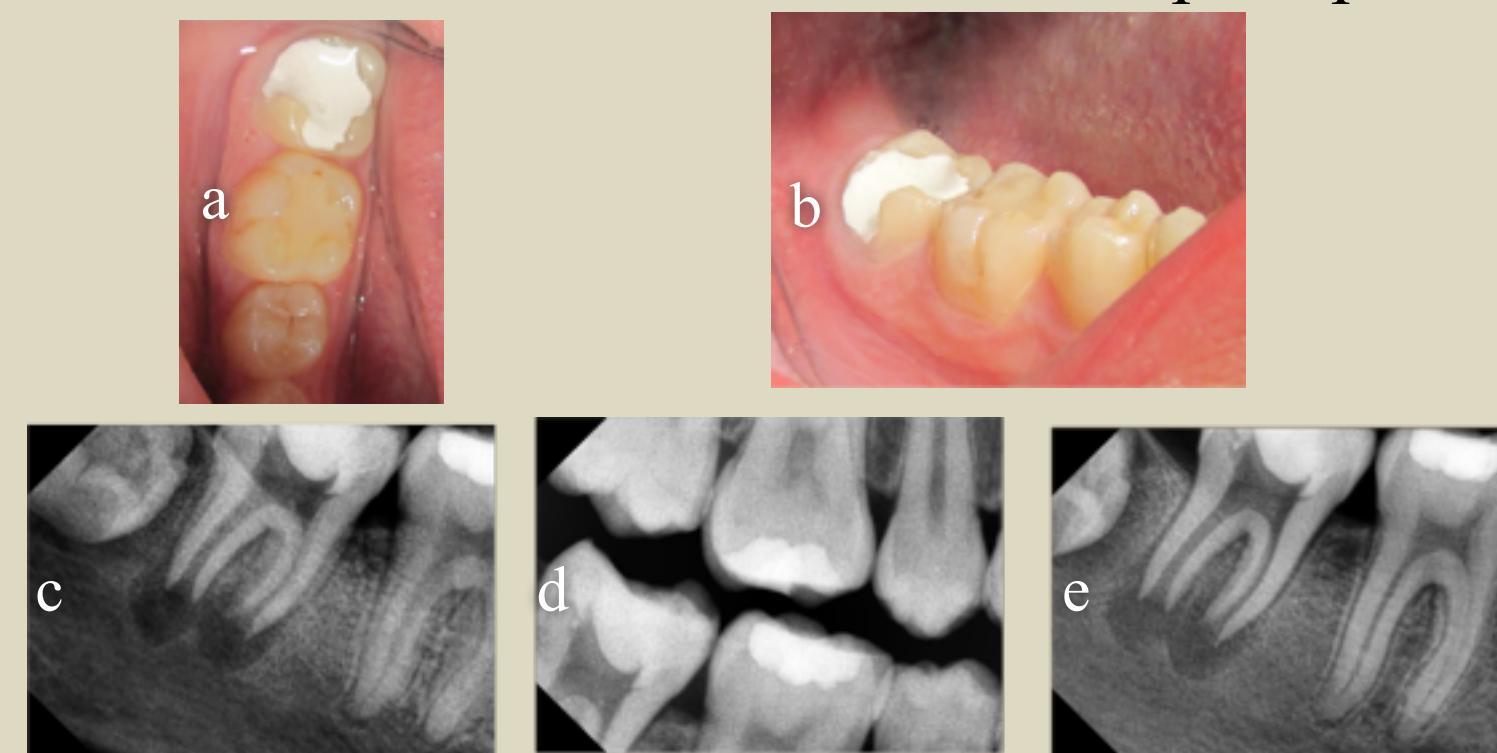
Preoperative clinical photographs (a, b) and radiographs (c, d & e) of right mandibular second molar
